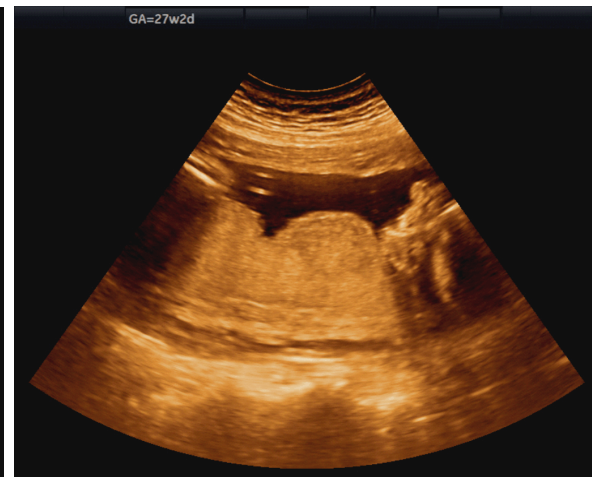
US at 27(+2) gestational weeks in a T1DM pregnancy demonstrating thick and immature appearance of placenta (G0). US: Ultrasound; T1DM: Type 1 diabetes mellitus (pregestational diabetes).
